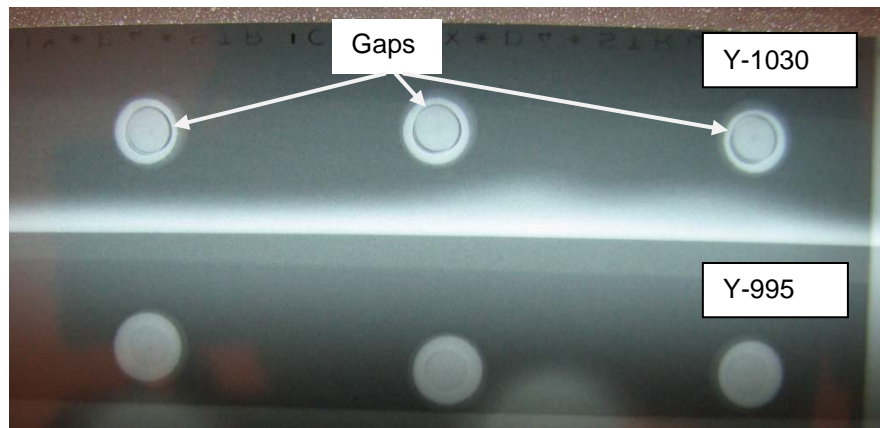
X-ray image showing examples of gaps between rivets and rivet holes (*Aircraft S/N 343*)
